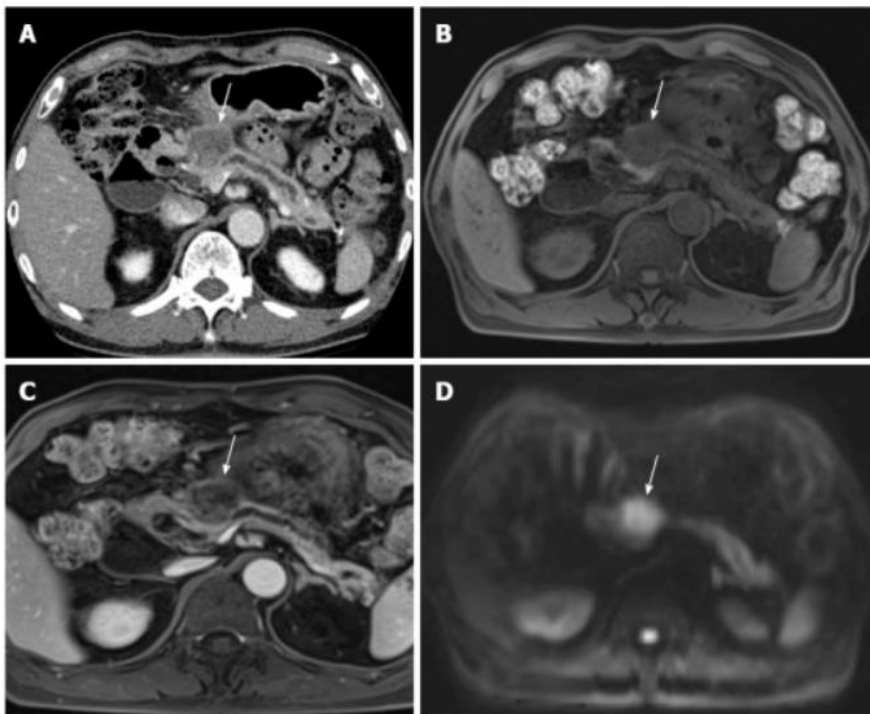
Differences in the soft-tissue contrast from MRI and CT scans in pancreas region in which arrow points the pancreatic head (A) CT scan, (B) T1-weighted gradient echo sequence of MR, (C) contrast administered MRI, (D) Diffusion-weighted MRI (Lee, E. S. & Lee, J. M., 2014)
